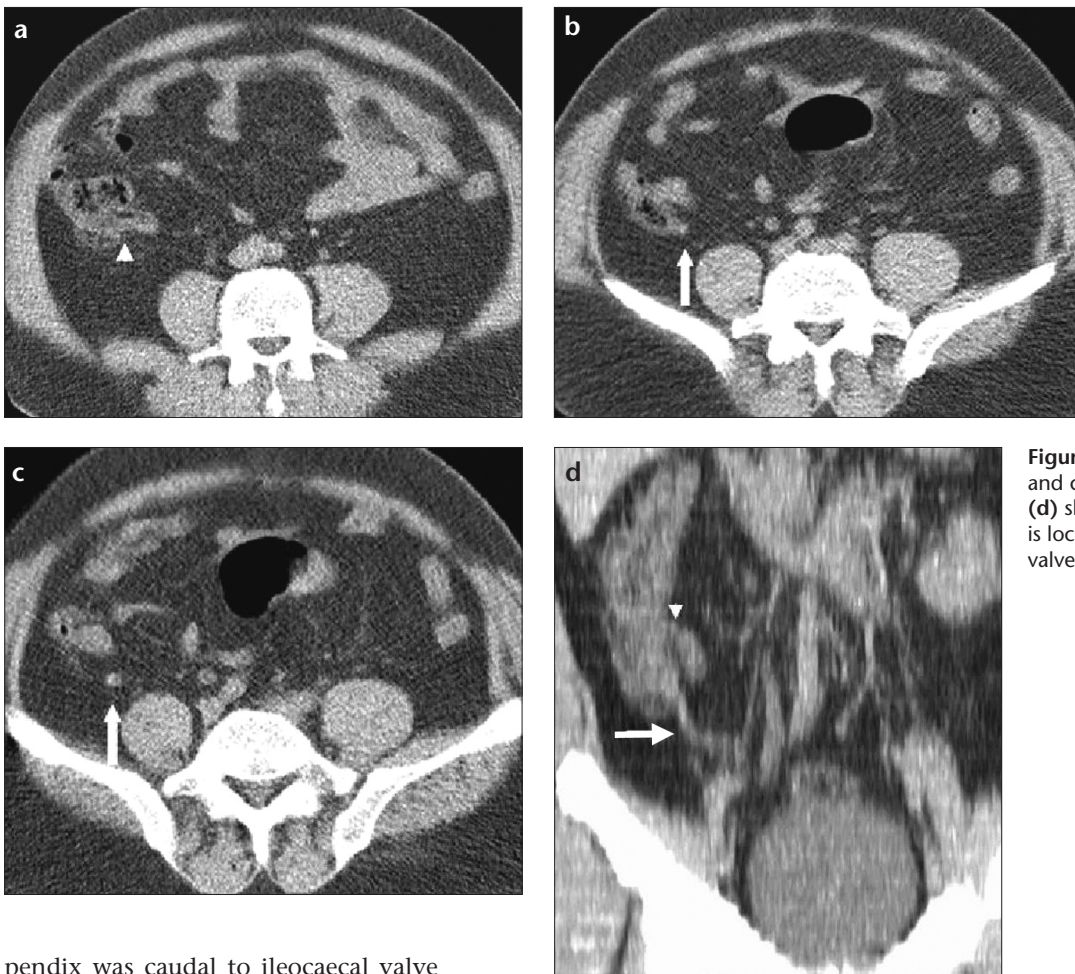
Axial CT sections (a-c), and coronal-oblique MIP image (d) show that root of the appendix is located caudal to the ileocecal valve.
